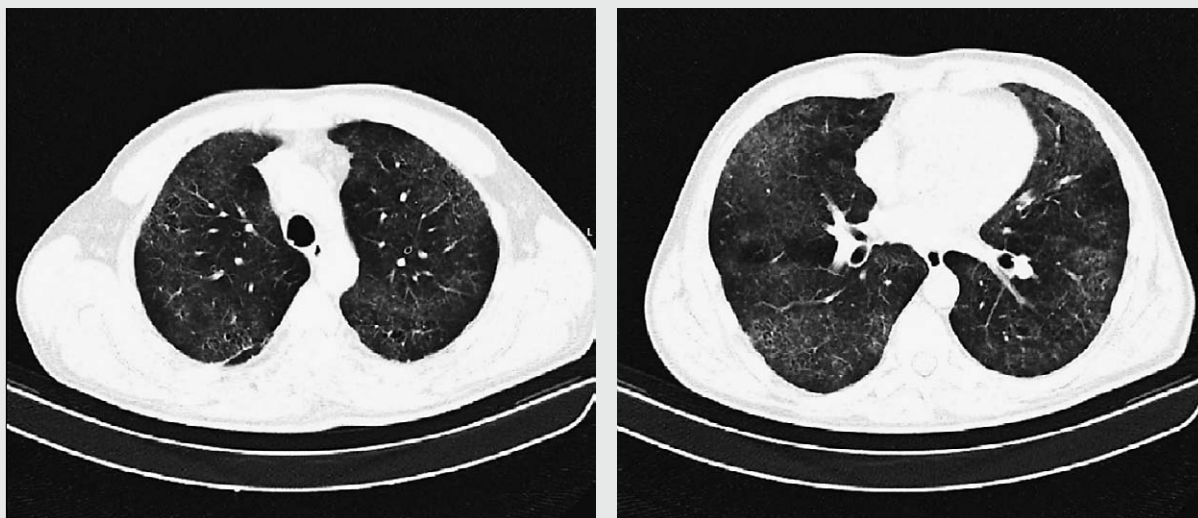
High-resolution computed tomography (HRCT) of the chest – axial section: interstitial lung disease
